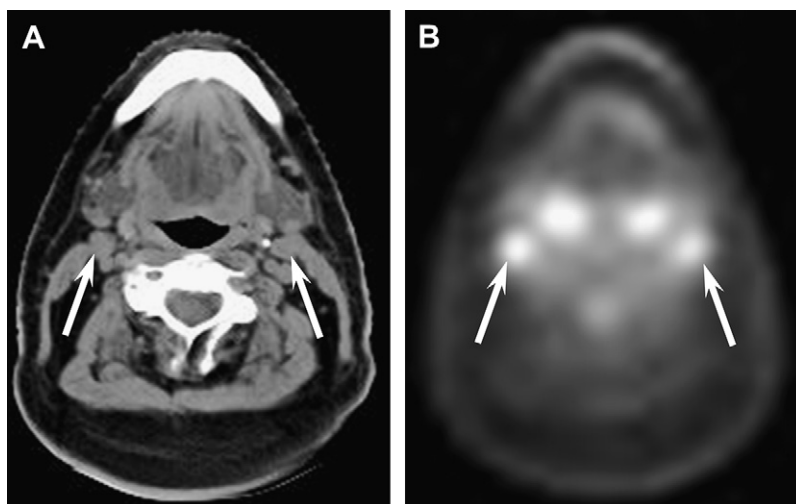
Combined PET and CT (PET/CT). (A) Axial CT image through the upper neck shows normal-sized, symmetric jugulodigastric nodes (arrows). (B) PET image at the same level demonstrates FDG avidity (arrows), indicating metastatic disease.
